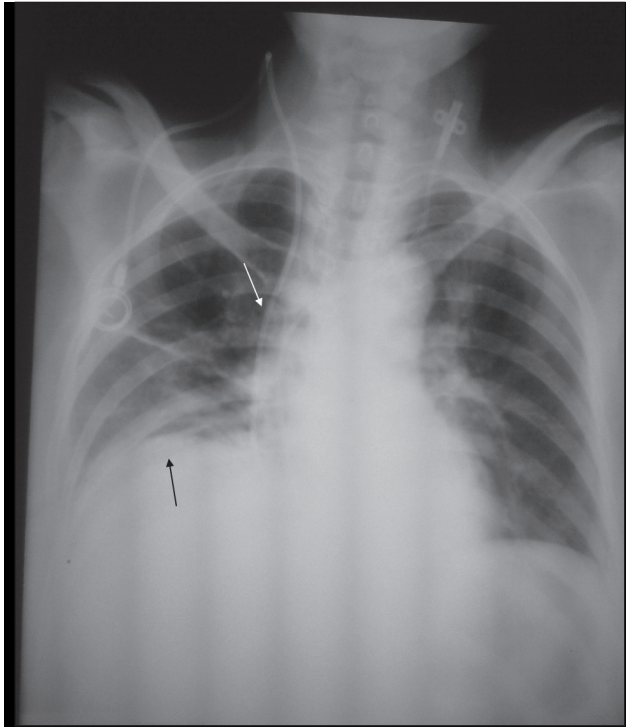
Chest radiography after drainage showing the drain oblique to the basis of the right hemithorax (black arrow), thickening and elevation of the catheter at the mediastinal path lateral to the right bronchus (white arrow).
